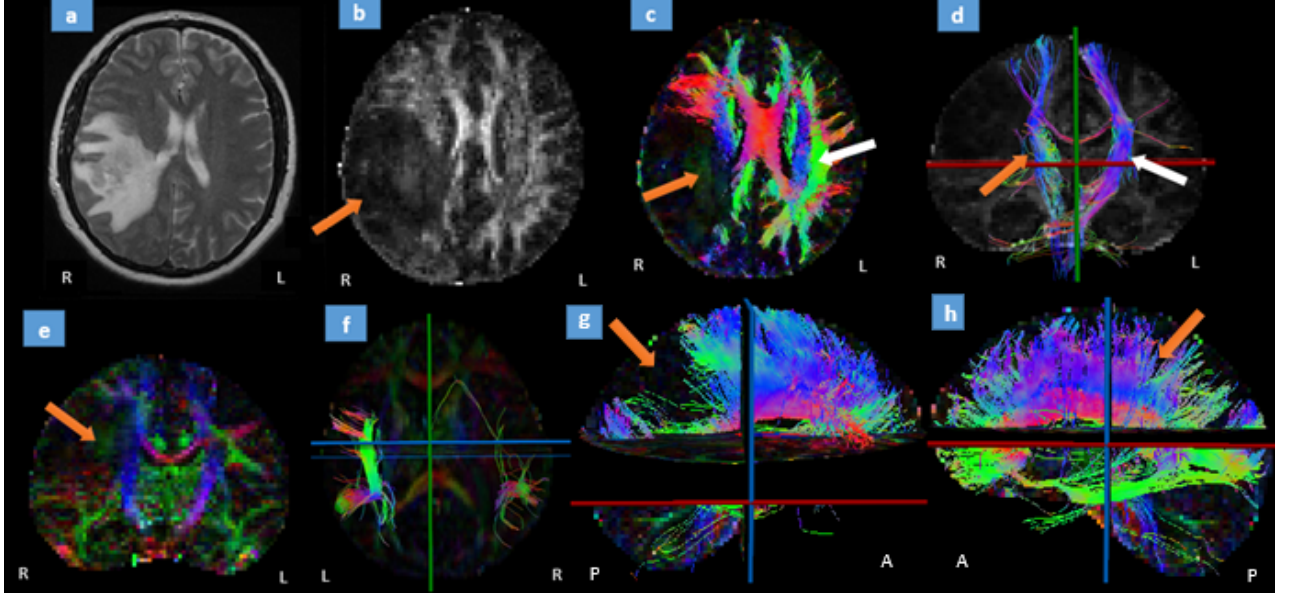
A 40-year-old female with right glioblastoma - T2-weighted image (a) shows the tumor in right primary motor area. Fractional anisotropy (FA) map (b) shows an intralesional decreased FA (arrow). Color-coded map (c) shows the intralesional white matter fibers of right superior longitudinal fasciculus (SLF) destroyed (orange arrow). The left SLF (white arrow) is intact and shown for comparison. 3D fiber tractography (d) shows blue-colored right CST (arrow) slightly deviated compared to the left CST (white arrow). Coronal slice color-coded map (e) shows the disruption of right arcuate fasciculus (AF) (arrow). The 3D fiber tractography of right AF is shown in (f) along with the intact left AF for comparison. The 3D fiber tractography (g) of right corpus callosum (CC) shows the destroyed fibers. The left intact CC (h) is shown for comparison. A: Anterior. P: Posterior. R: Right. L: Left.
